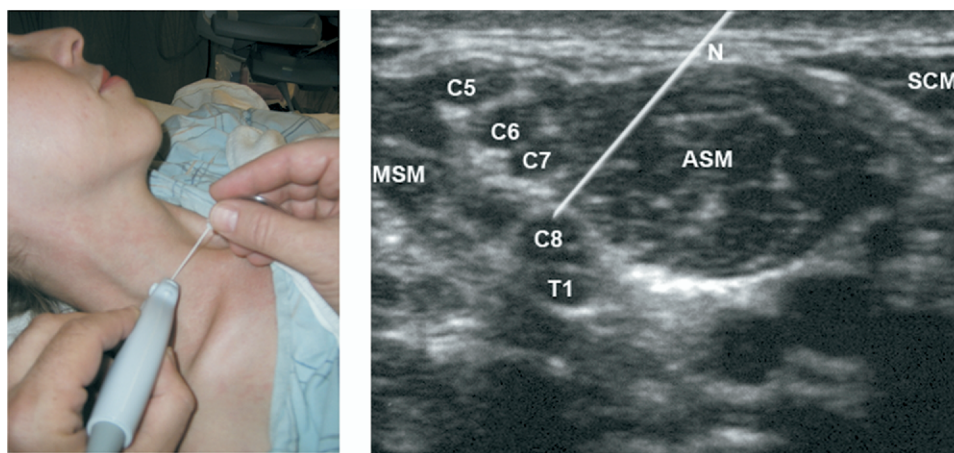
Ultrasound-guided interscalene block. (A) In this example, the needle is introduced from an antero-medial to postero-lateral direction, in-plane with the transducer, which is held in an axial oblique orientation. (B) Ultrasound scan of real-time needle guidance during interscalene block. N = needle (enhanced with photo editing for emphasis); C5-T1 = cervical and first thoracic nerve roots; ASM = anterior scalene muscle; MSM = middle scalene muscle; SCM = sternocleidomastoid muscle. (Color version of figure is available online.)
